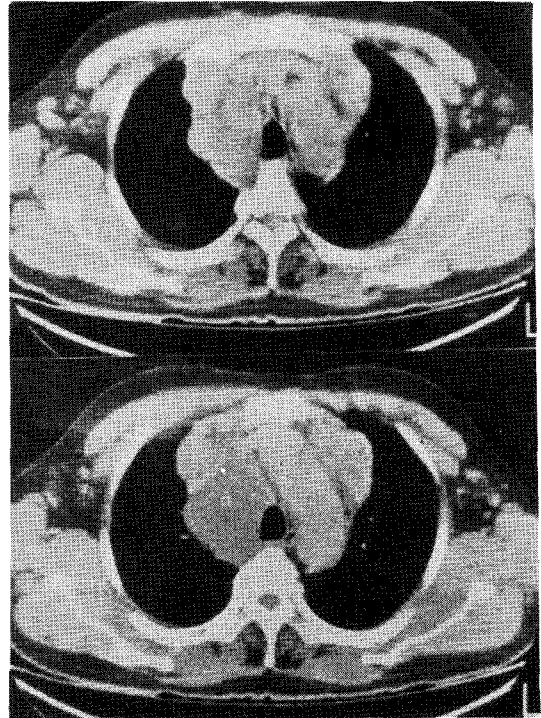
Upper : Pre-contrast CT showing that multiple nodular soft tissue masses are aggregated and well demarcated from adjacent aorta and trachea. Bottom : Post-contrast CT shows that these masses are moderately (50–70HU) enhanced.
